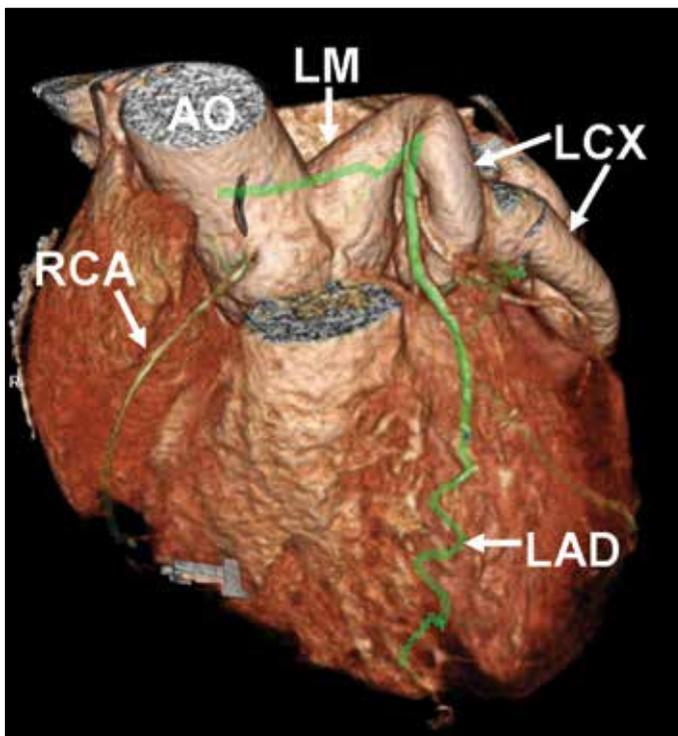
Three-dimensional computed tomographic volume-rendered reformation shows origin of the left main coronary artery (LM) and right coronary artery (RCA) from the aortic sinuses. And it shows a large and tortuous left circumflex coronary artery (LCX), dilated segments of the left main coronary artery (LM) in comparison with the left anterior descending artery (LAD)
